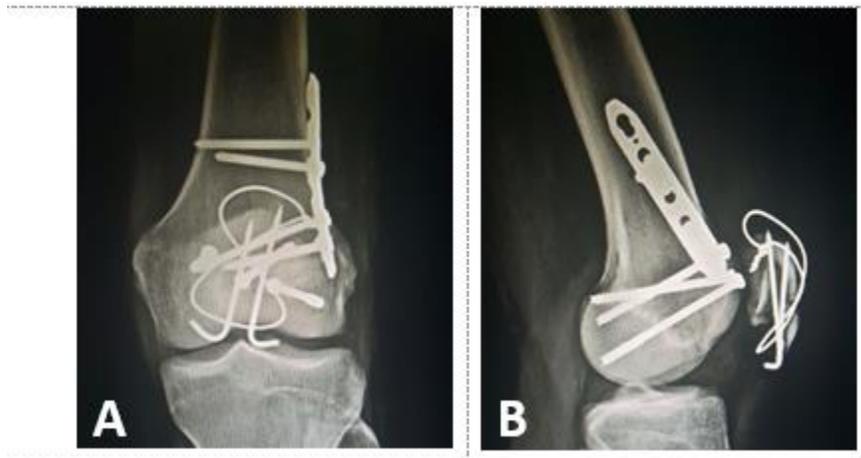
Xray Left AP and Lateral View Distal Femur with patella
